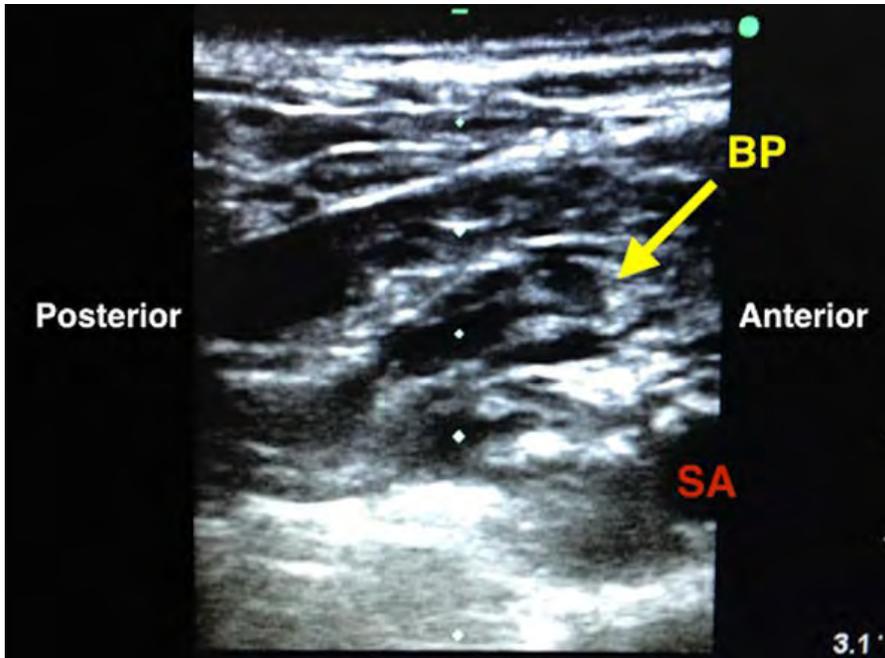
Ultrasound image during supraclavicular nerve catheter placement. (BP = brachial plexus, SA = subclavian artery).
